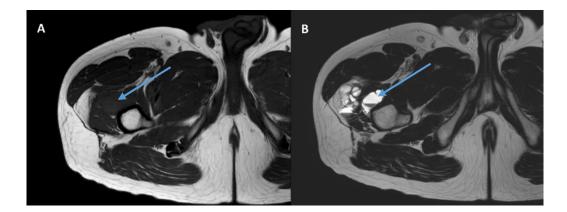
MRI of synovial sarcoma in the hip area. A) T1 weighted, transverse view and B) T2 weighted, transverse view.
